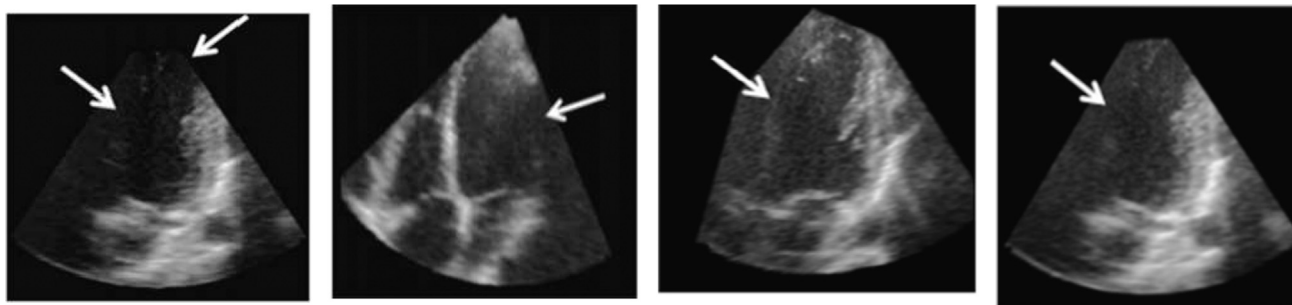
The 2D cross-sections from 3DE images show example echocardiographs of heart taken from different transducer positions, where the arrows indicate intensity dropout and missing anatomical structures [5].
